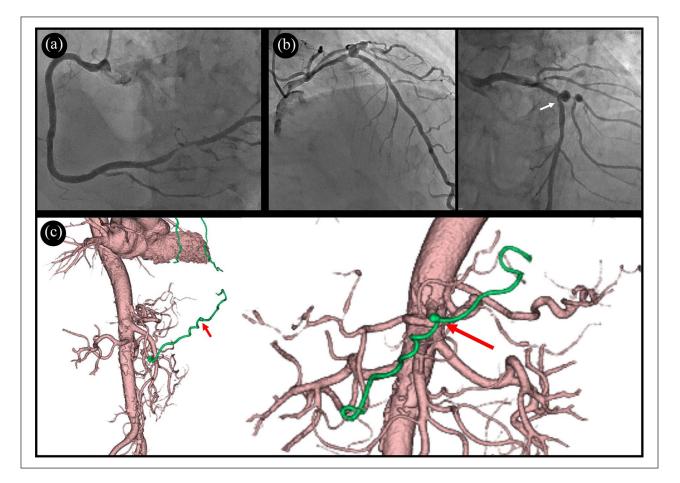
Preoperative images. (a) Ninety percent stenosis at the atrioventricular node branch. (b) Left coronary artery: a small aneurysm in the left anterior descending artery and first diagonal branch artery; 75% stenosis at the mid-portion of the left anterior descending artery; 99% stenosis at the diagonal branch artery. Stenosis is observed on the distal side of the coronary aneurysm, as indicated by the white arrow. (c) Preoperative three-dimensional computed tomography. A small aneurysm is observed in the right epigastric artery, as indicated by the red arrow.
